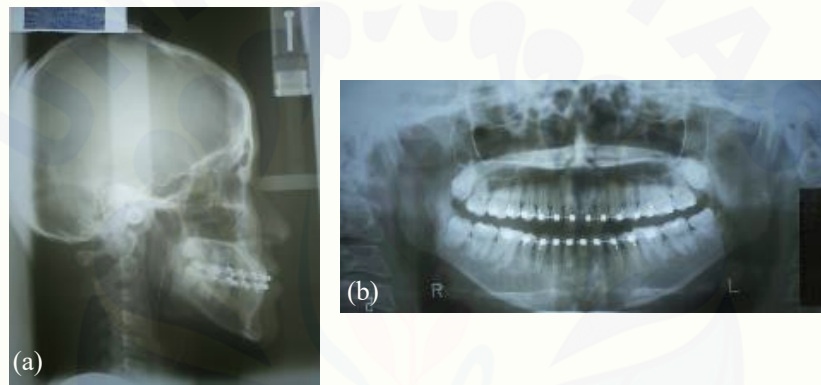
Pre-debonding (a) lateral cephalometric and (b) panoramic radiographs.
